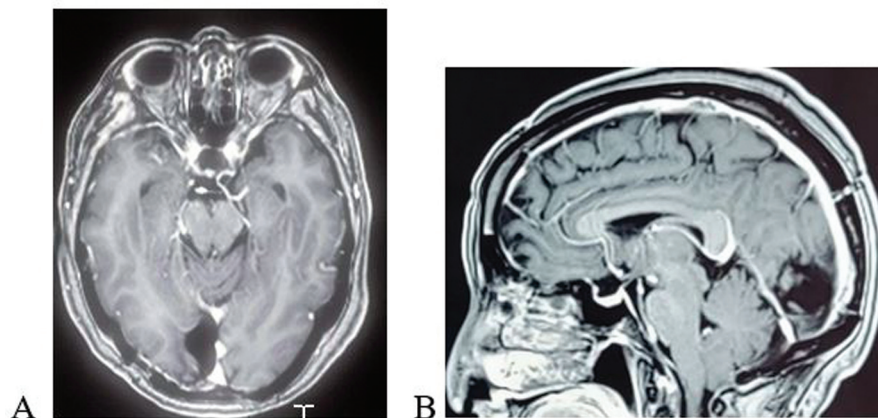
Brain magnetic resonance imaging (MRI). (A and B) T-weighted MRI, showing non-enhancement of both surgical sites after gadolinium administration, suggestive of absence of residual tumor.
